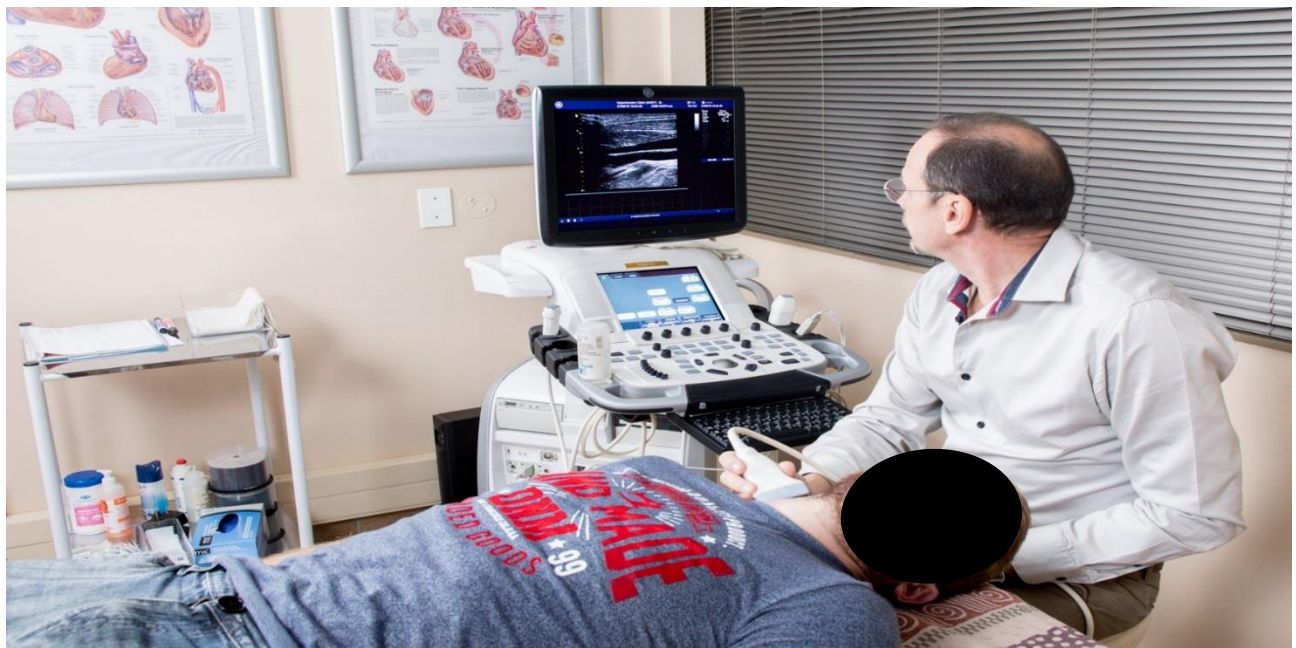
A researcher using the General Electric Vivid E9 ultrasound device to measure the carotid intima-media thickness of a participant in the African-PREDICT study.
